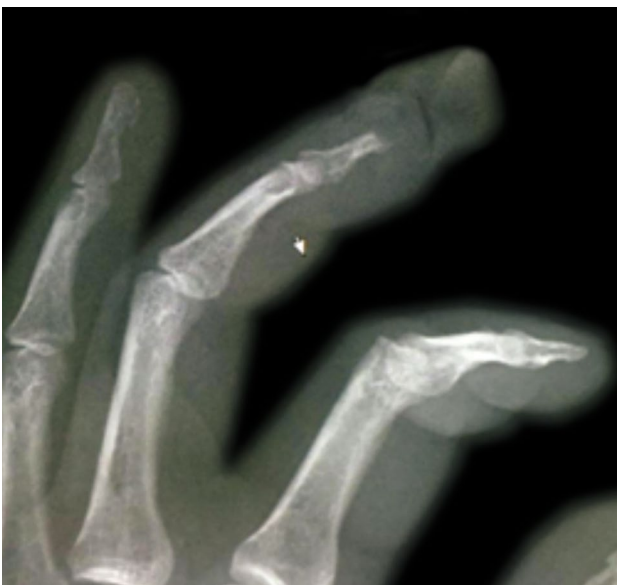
A postoperative oblique radiograph confirming the partial excision of distal phalanx at an appropriate level.
